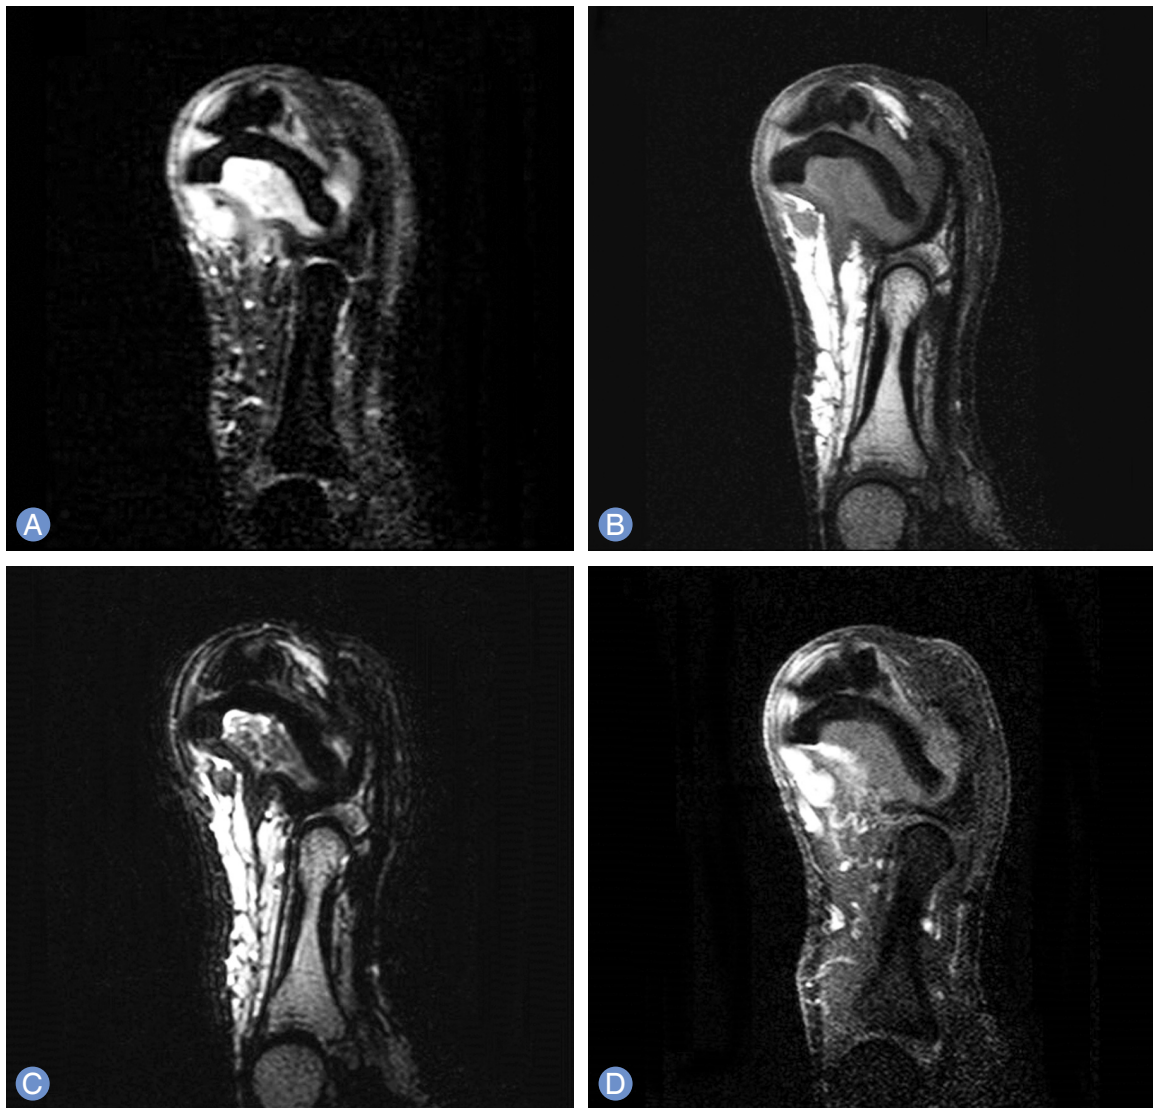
(A) Fat suppression Image. (B) T1-weighted image, (C) T2-weighted image, (D) gadolinium enhanced Image. On magnetic resonance imaging finding, 23×13 mm sized low signal mass showed segmented horn shape growing from dorsal distal interphalangeal joint to distal area. This mass contained fat tissue on T1, T2 and fat suppression image. In the distal fatty part of mass, heterogeneous enhancement with necrotic change was shown suggesting malignant tumor such as liposarcoma on T1 and gadolinium enhanced image.
